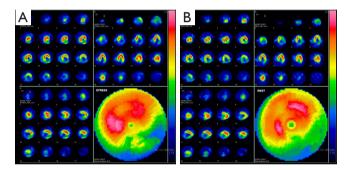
Single-photon emission CT showing no irreversible ischemia in the territory of the LAD artery. The territory of the RCA shows no myocardial viability. (A) Images after pharmacological stress; (B) images at rest. LAD, left anterior descending; RCA, right coronary artery.
